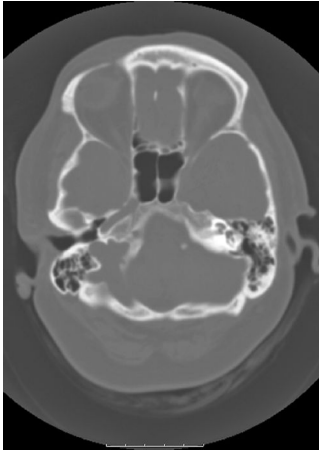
This is a different slice through the brain with the CT windowing set to show the bones. This is used to seek fractures (e.g. after a fall and head injury). © Anthony Pereira.
